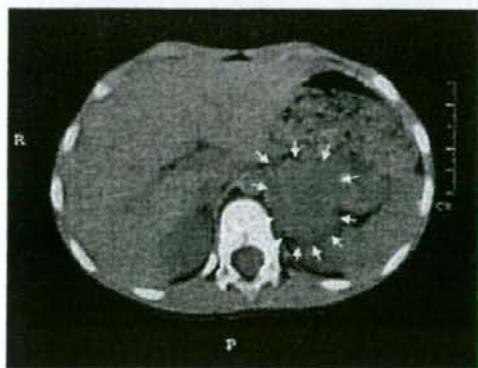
Computed tomography and the resected tumor. Computed tomography of the abdomen revealed a 4 × 4 cm round mass in the left adrenal gland. The mass was homogeneous and isoattenuated relative to the kidney.
